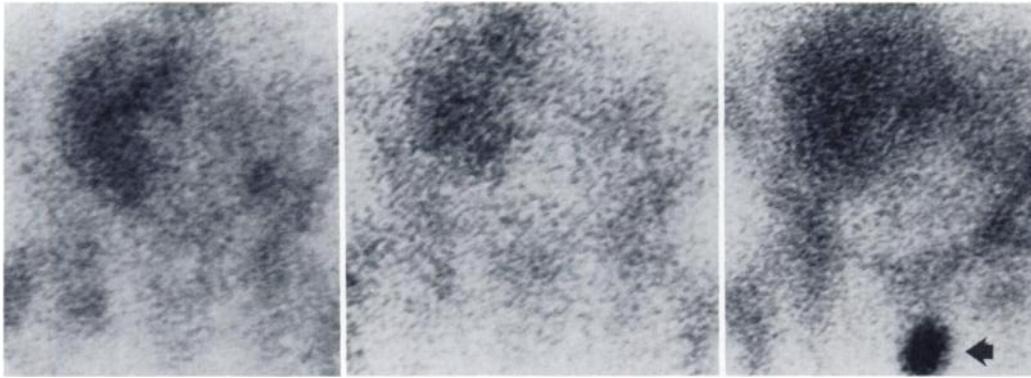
Initial ILL scintigram at 72 hr (left) shows renal allograft activity surpassing that in adjacent lumbar spine. Initial ILL scintigram at 96 hr (center). Repeat ILL scintigram 2 wk later (right) identifies very intense activity in vaginal abscess (arrow). Renal allograft activity is unchanged.
